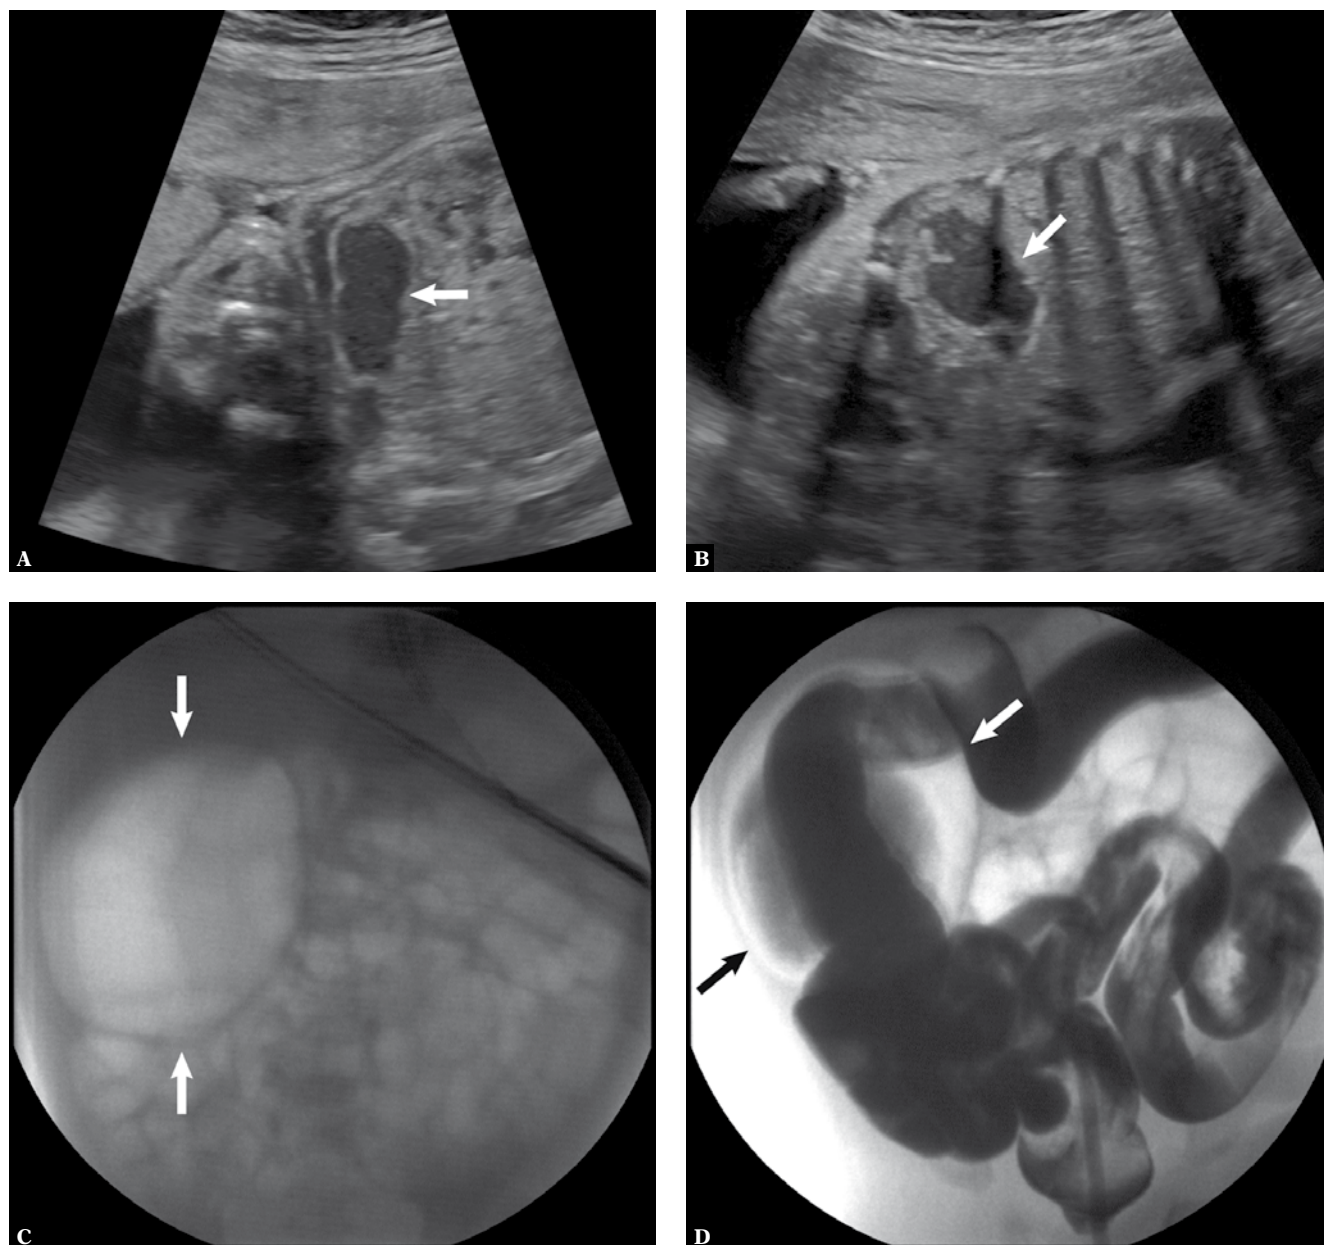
Intestinal duplication. A. Fetus at EMA of 29 weeks 6 days. Ultrasound demonstrates the lesion at rest (arrow). B. Lesion (arrow) during peristalsis. C. One-day-old newborn. Abdominal radiograph shows gas in the lesion (arrows) with an otherwise normal gas pattern D. Contrast enema shows opacification of the colon and a large portion of the small bowel. The contrast also entered the lesion (arrows)
